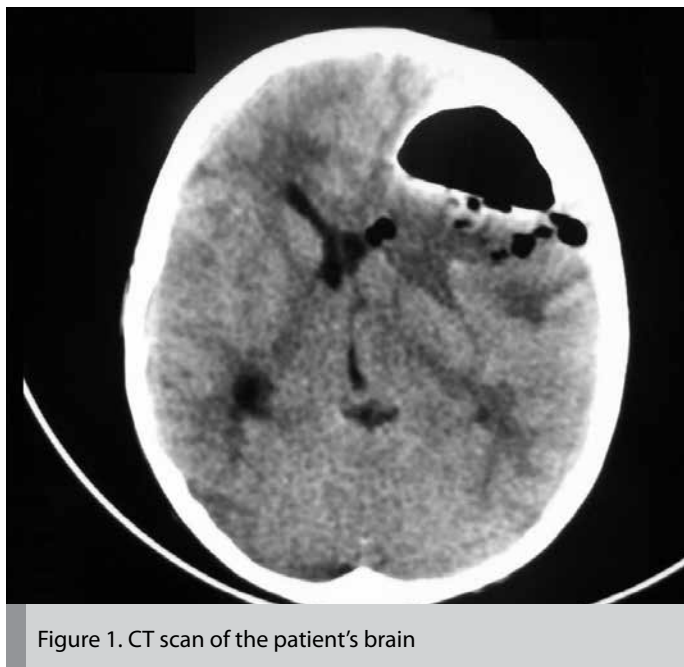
CT scan of the patient's brain
